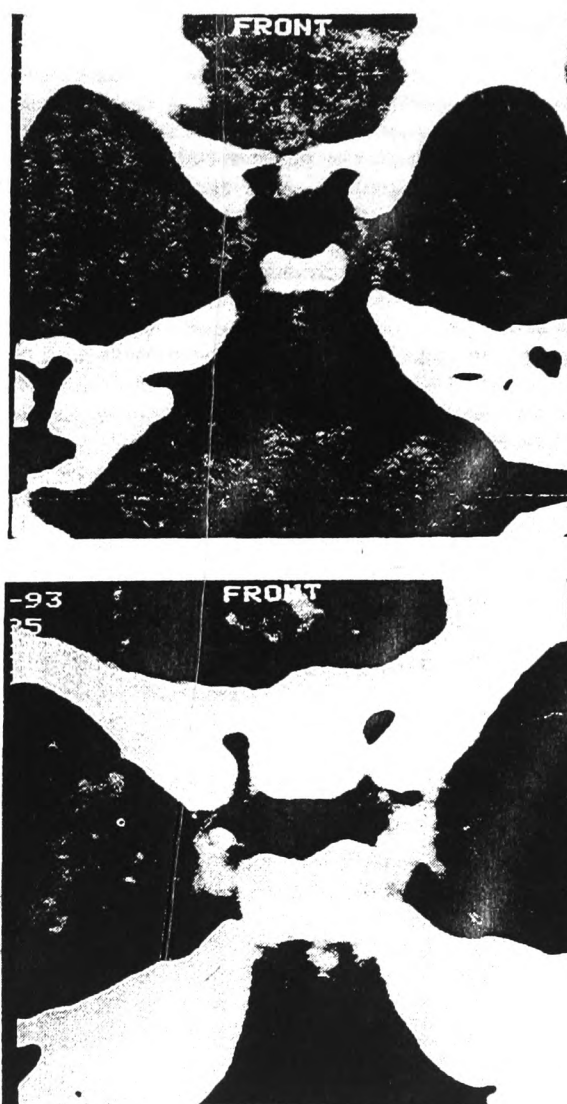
CT of a 10-year-old girl with SCD: (a) CT without i.v. contrast medium; and (b) CT taken after i.v. injection of contrast medium. Attenuation values of the sella contents were between  $-35$  and  $8$  Hounsfield Units; compatible with partial empty sella with fatty degenerative changes.
